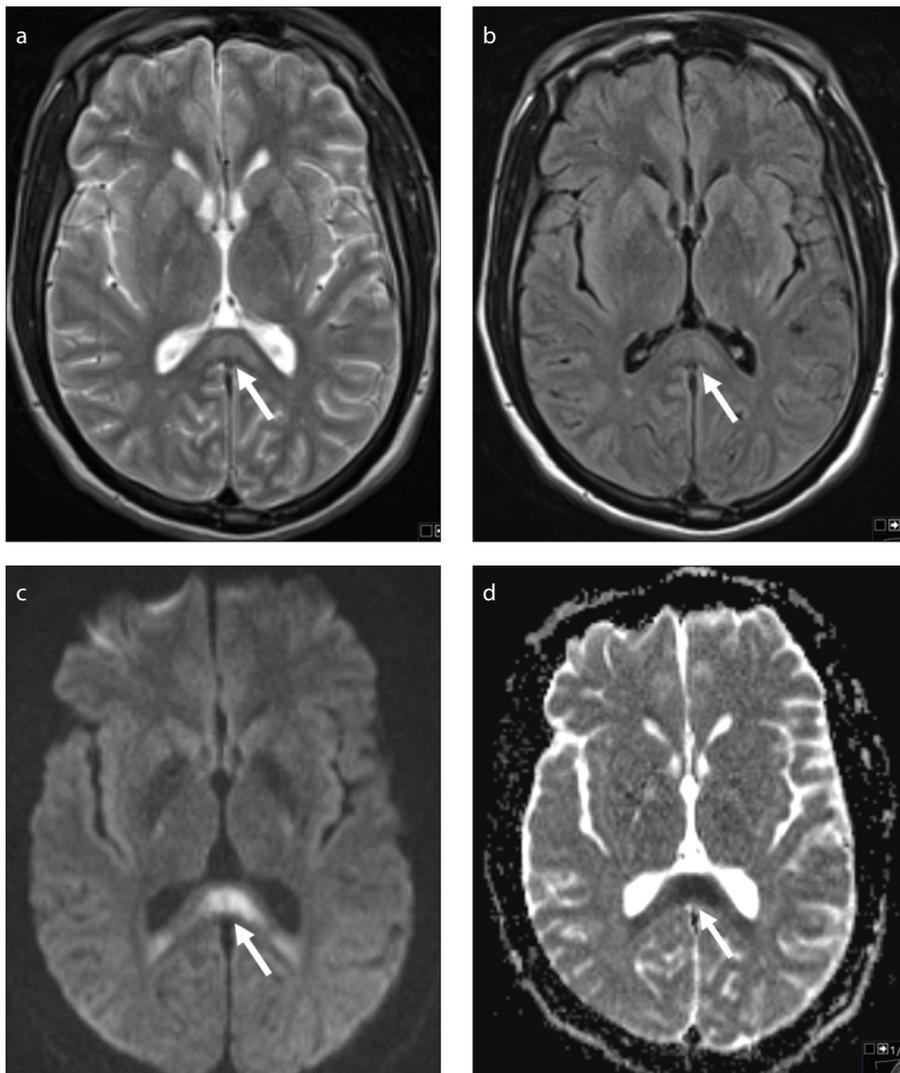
a–d. A 44-year-old woman with metastatic melanoma undergoing HDIL-2 therapy presented with altered mental status and gait instability. Axial T2-weighted image (a) and axial FLAIR image (b) demonstrate hyperintense lesion in the splenium of the corpus callosum (arrows). Diffusion-weighted image (c) and ADC map (d) reveal diffusion restriction of the lesion (arrows). The findings suggested HDIL-2 related encephalopathy. The patient's symptoms resolved following the cessation of HDIL-2 therapy.
